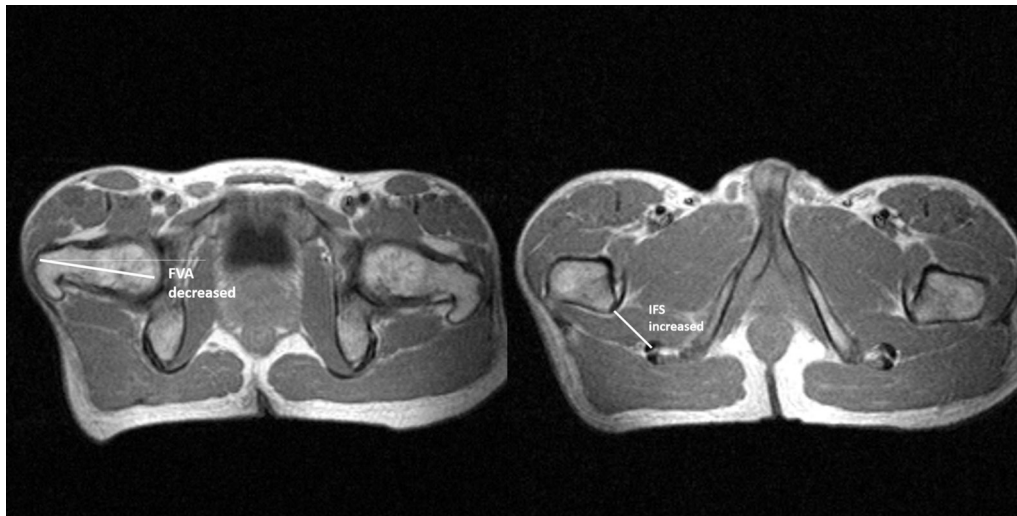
Axial hip MRI with SE T_1 WI sequence. There was a negative relationship between the FVA and the IFS. Image showing (A) decreased FVA and (B) increased IFS. FVA, femoral version angle; IFS, ischiofemoral space; T_1 WI, T_1 weighted imaging.
